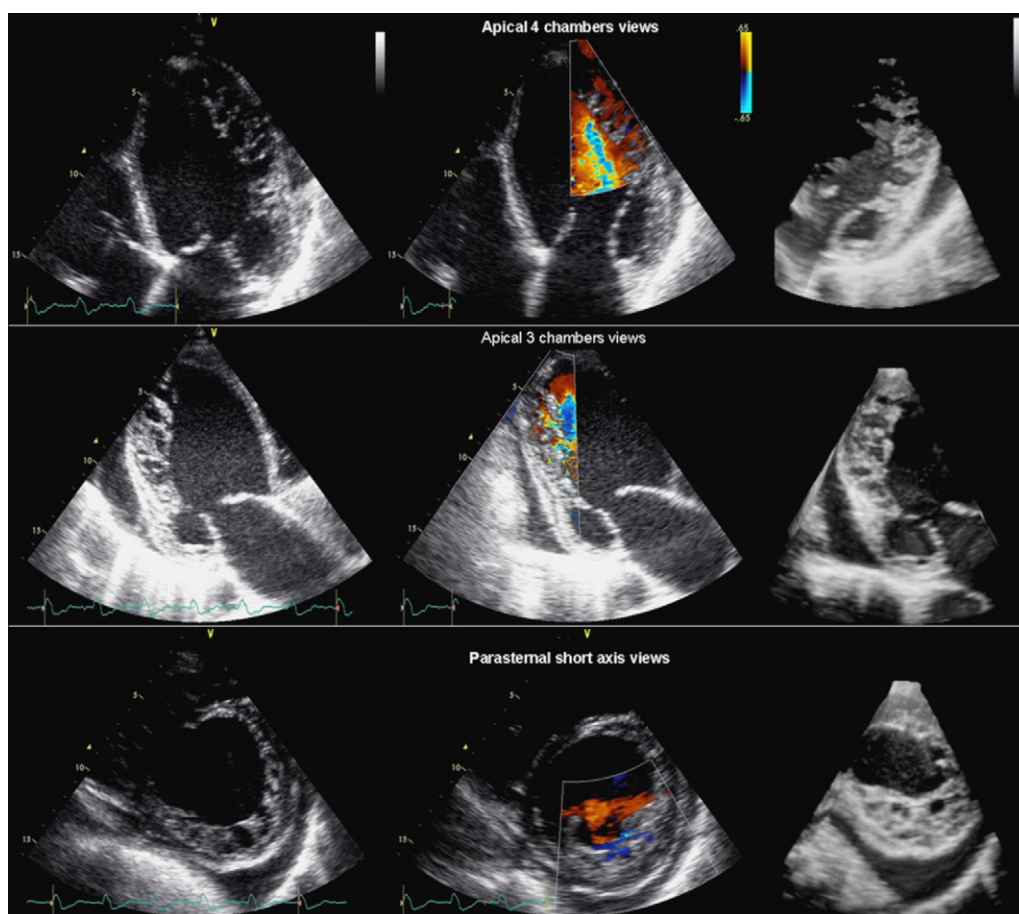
Two- and three-dimensional echocardiographic images of left-ventricular non-compaction.
